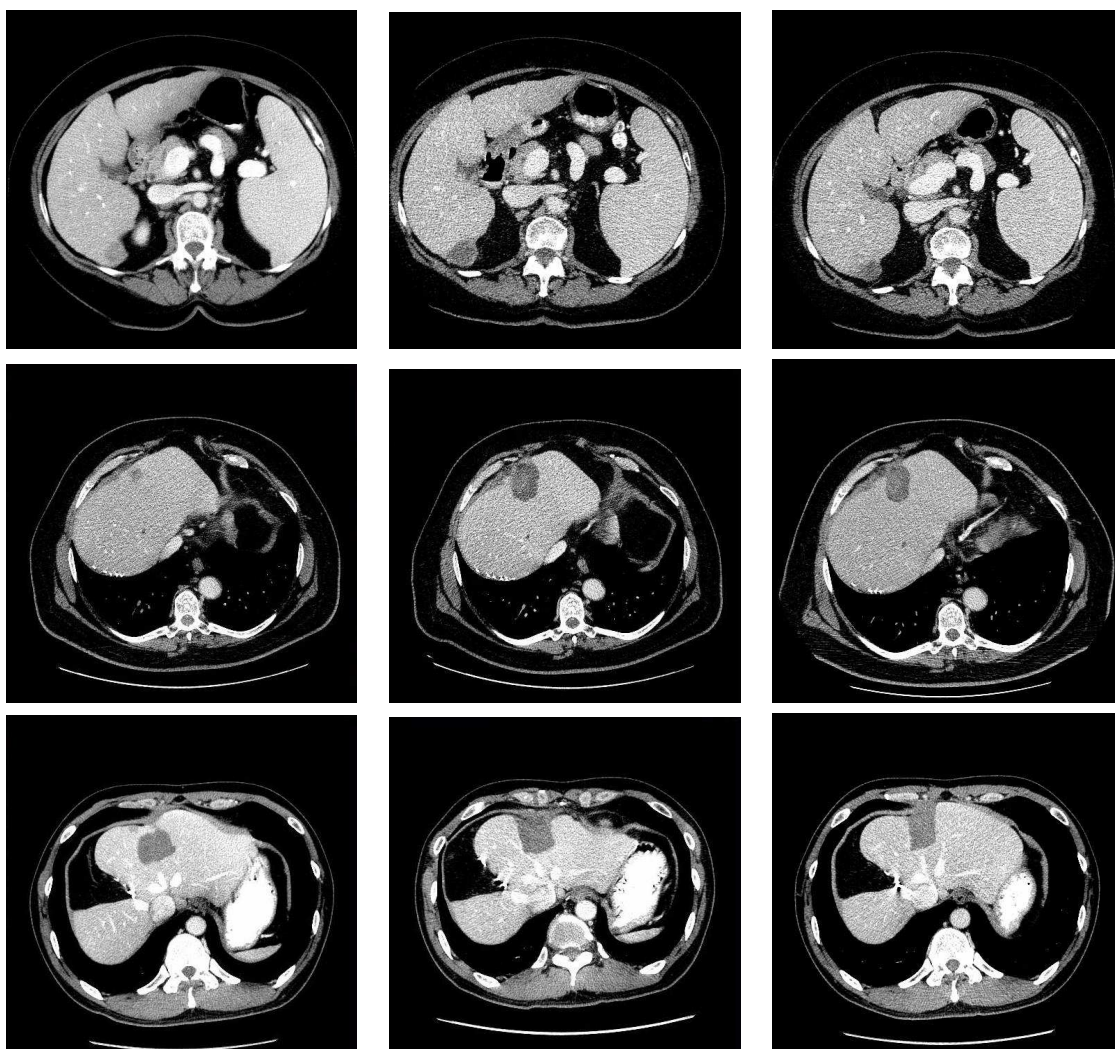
CT scans for three patients treated by per-cutaneous radiofrequency ablation of HCC : the first column the pre-treatment images, the second column 1 month follow-up, and the third column 3 months follow-up. The last patient was re-evaluated for suspected relapse, thus the pre-treatment image is considered after the first RFA.
